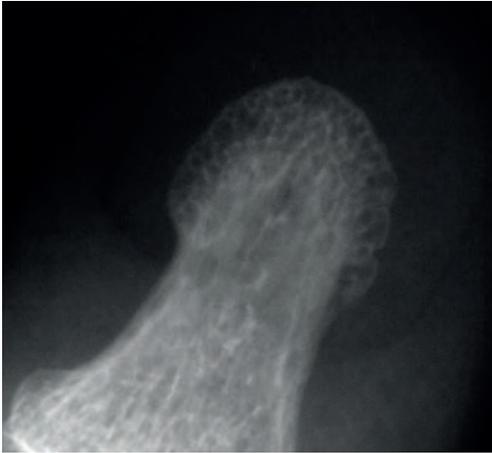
Radiograph of the tip of the finger. The outer circumferential cortical is maintained functionally (or at least modulated) by the finger nails, which create a counter-pressure while the fingers grab items.
